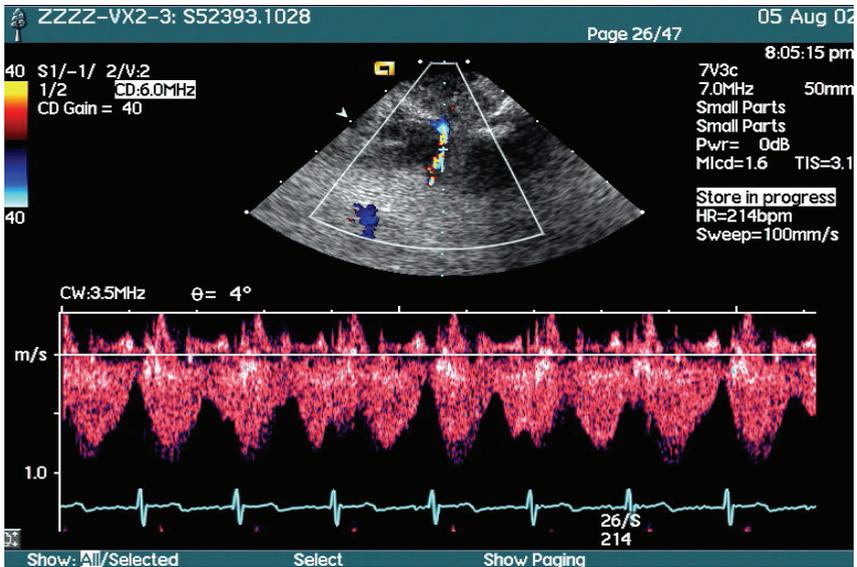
SVC Doppler flow waveforms before the radiotherapy
